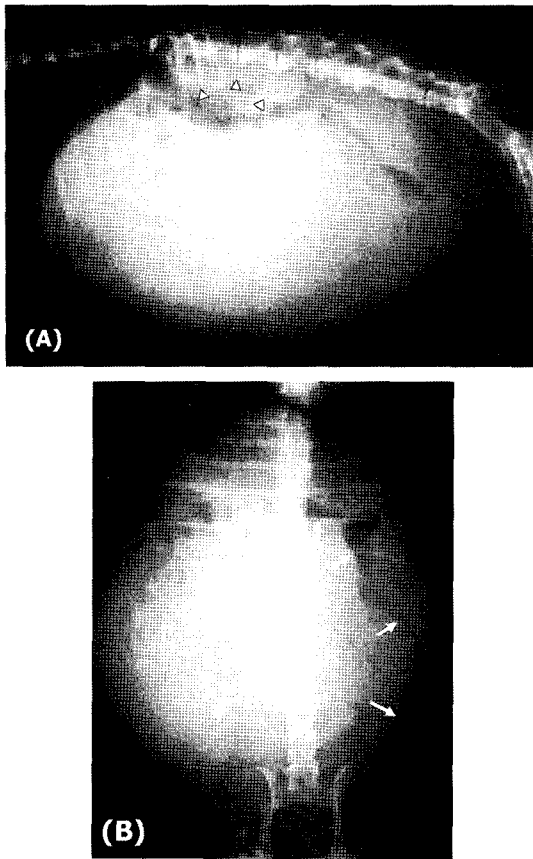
Lateral (A) and ventrodorsal view (B) of the abdominal radiography. Uniformly distributed homogenous soft tissue density is observed throughout the distended abdomen. The craniolateral displacement of gas-trapped intestine (arrows) and dorsal shift of left kidney (arrow heads) are shown.
